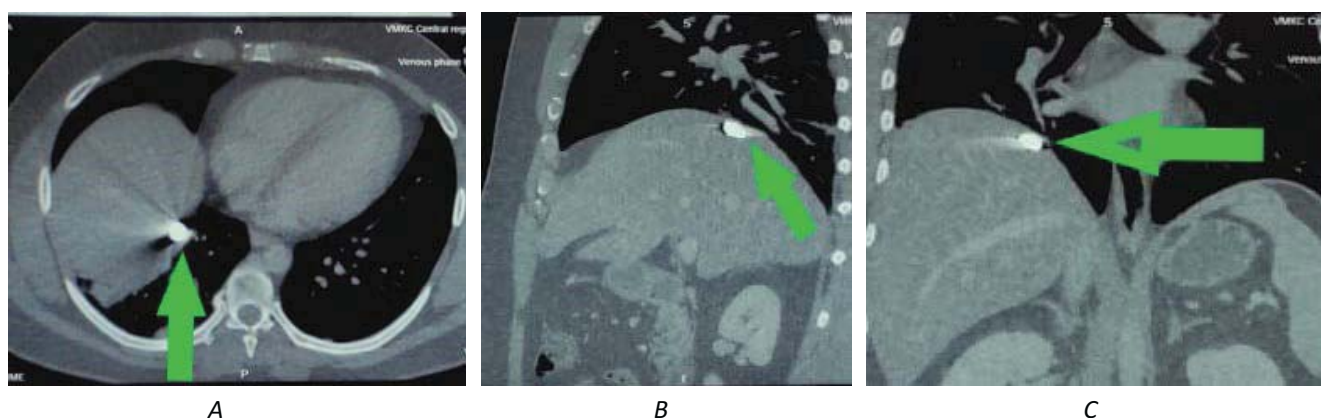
Results of the chest and abdominal organs multispiral CT: green arrows indicate the metal fragment location along the liver VIII segment diaphragmatic surface: A – axial projection; B – coronal projection; C – sagittal projection
